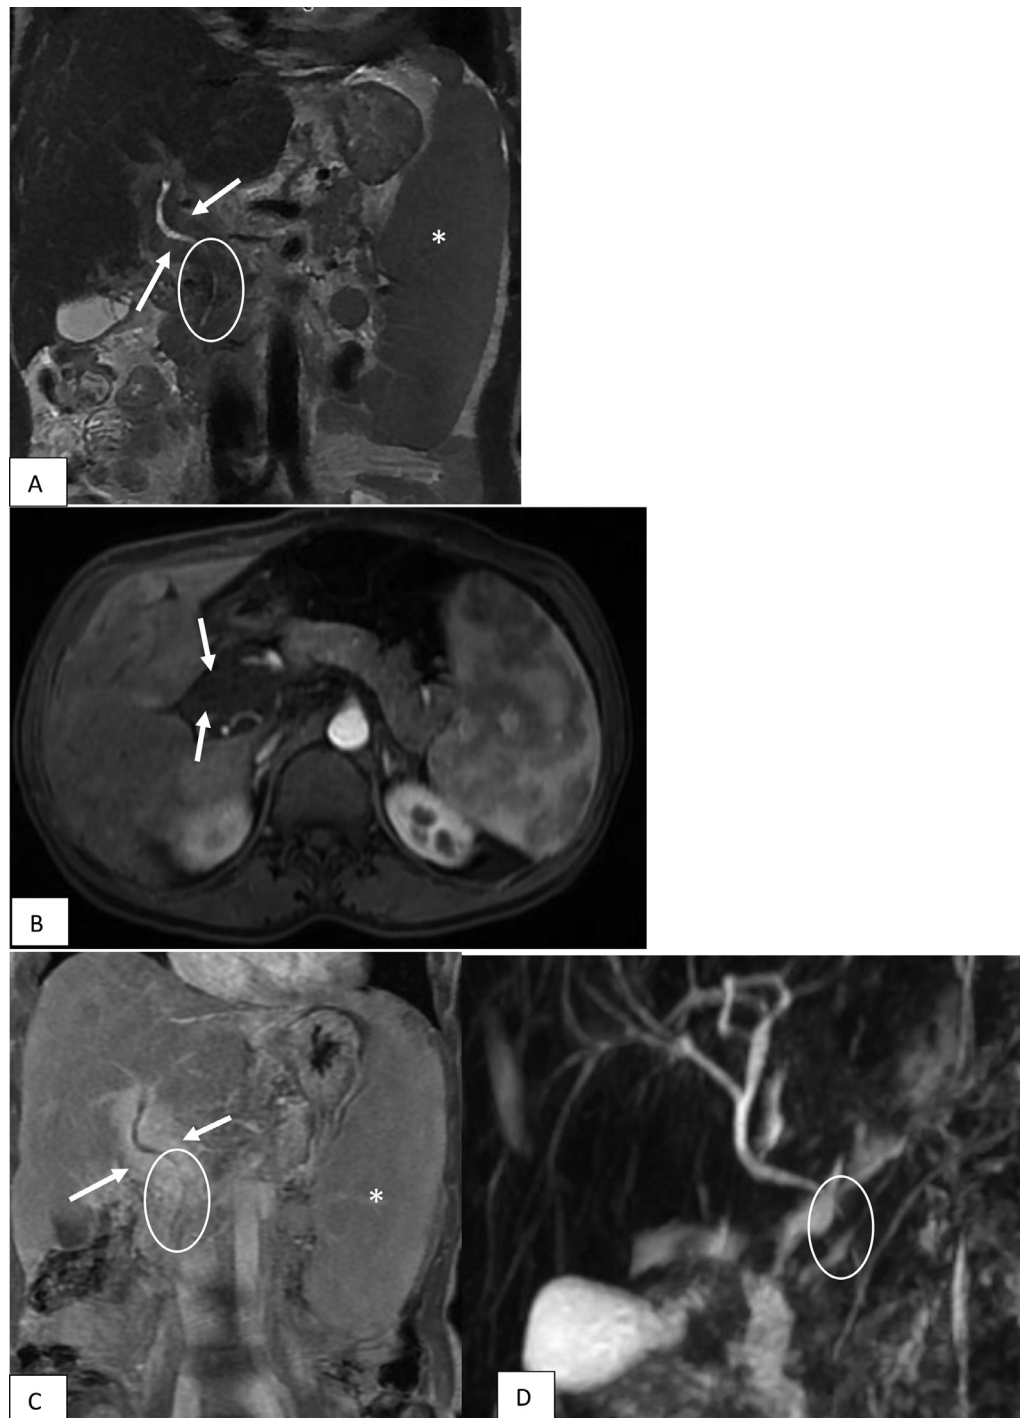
The coronal T2-weighted image (A) showed an intermediate signal sleeve developed around the CBD at the hepatic pedicle, this sleeve exhibited no enhancement in the arterial phase on Fat-sat T1 weighted image (B), with intense and homogeneous enhancement in the portal phase on Fat-sat T1-weighted image (C), causing compression on the CBD in the 3D-MRCP. Notice Significant splenomegaly was noted (*).
